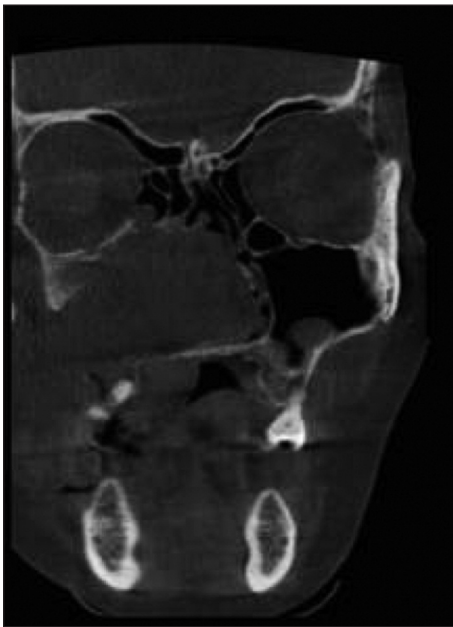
Coronal section on cone beam computed tomography revealed cortical destruction of the walls of the right maxillary sinus and medially invaded into the right nasal cavity, orbit and pterygopalatine fossa, ethmoid sinuses.
